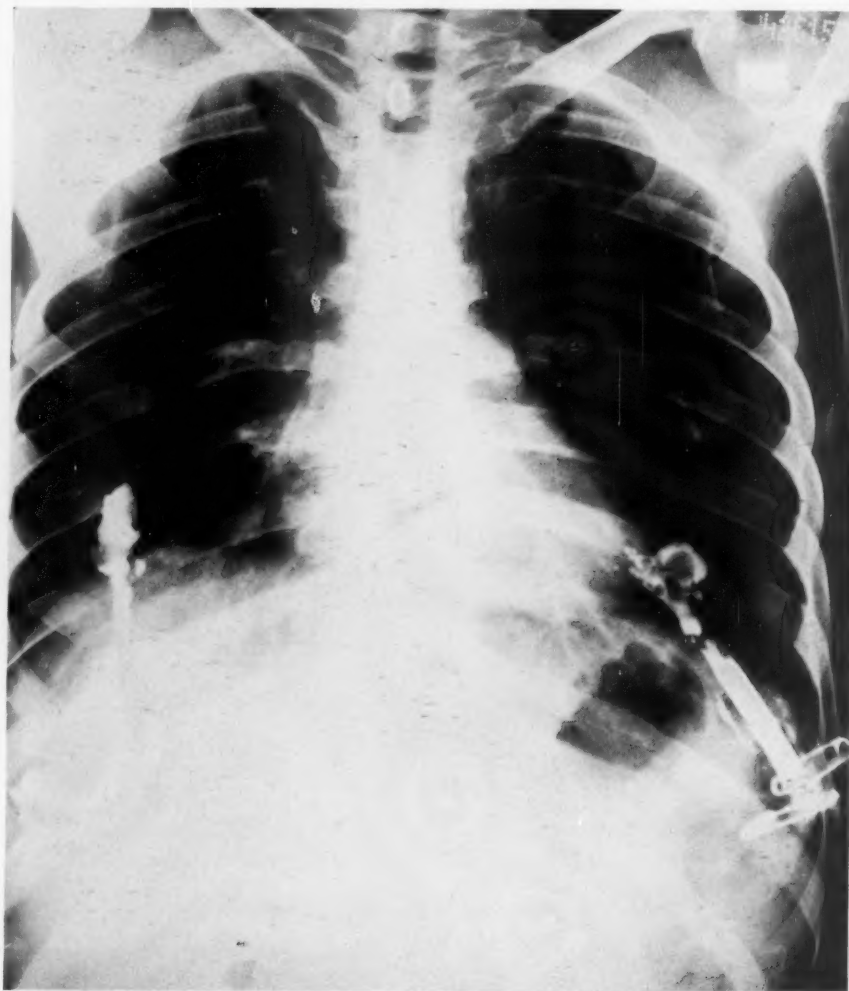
Case 12, Table I: Postero-anterior roentgenogram taken 31 days following drainage of the empyema on the left side, and 29 days after the drainage of that on the right side; iodized oil has been injected into the sinuses.
